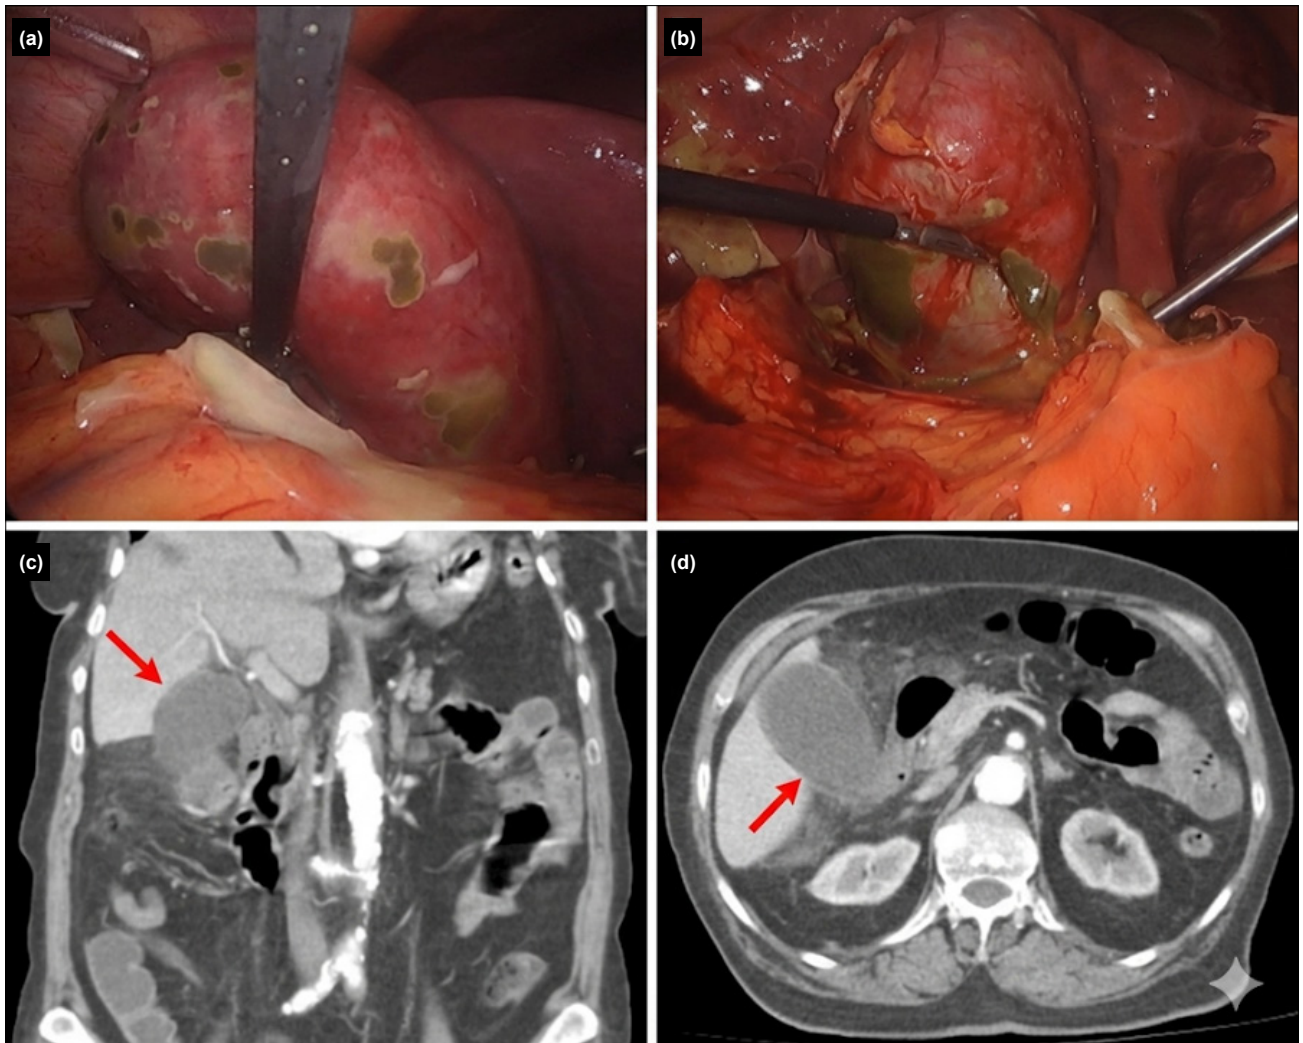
Representative intraoperative and cross-sectional imaging findings of gangrenous cholecystitis. (a and b) Intraoperative laparoscopic views. (c) Coronal and (d) axial preoperative contrast-enhanced computed tomography images (arrows indicate the gallbladder).
